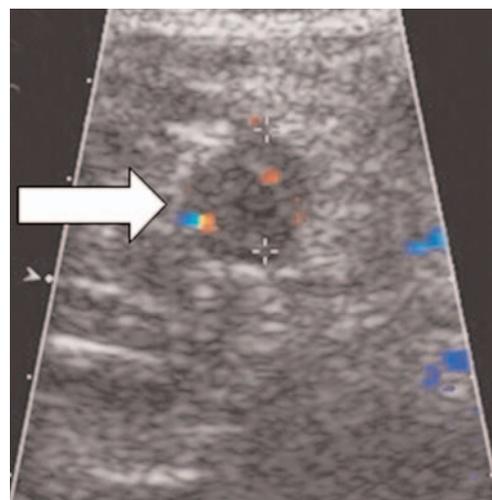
Acute appendicitis on ultrasound. Finding a greater than 7-mm outer diameter noncompressible appendix is virtually diagnostic for acute appendicitis. This appendix (white arrow) is 12 mm in outer diameter. There is some flow in the appendix, but color Doppler is generally not useful in ultrasound diagnosis of acute appendicitis.
